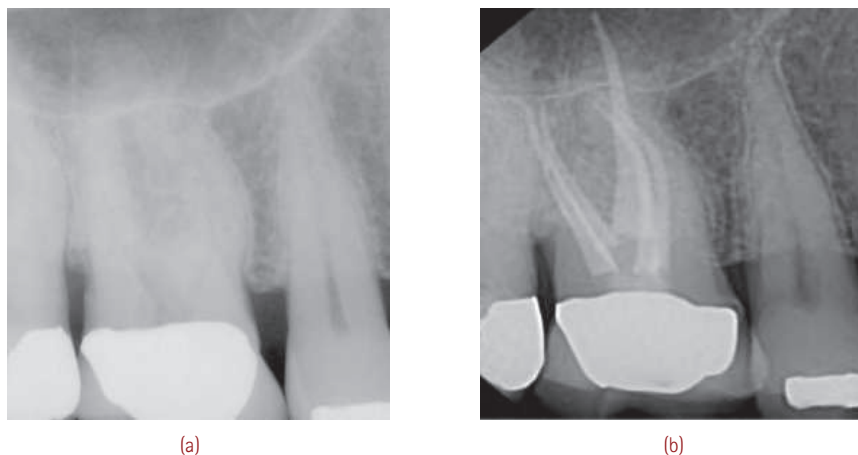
(a) Preoperative radiograph of the maxillary first molar indicative of the possibility of extra canals. (b) Postoperative radiograph showing evidence of five canals with two canals each in the mesiobuccal and distobuccal roots. (Courtesy: Julian Webber, England.)
